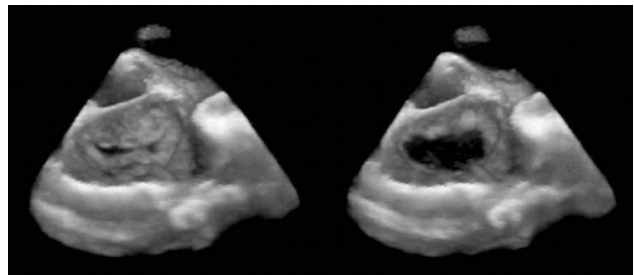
A 3-dimensional echocardiography image of the mitral valve from the left atrial.
